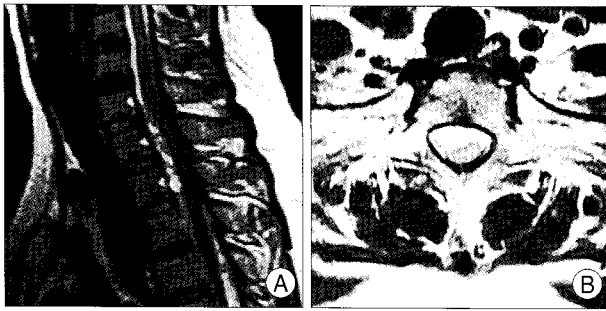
Case 3. A : Preoperative sagittal T2-weighted image shows epidural hematoma at C7-T4. B : Axial T2-weighted image shows hematoma with cord displacement.
